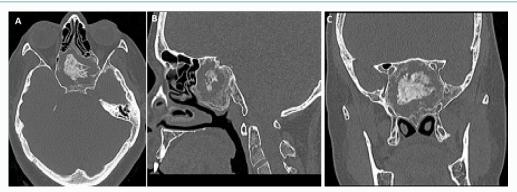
Paranasal sinus computed tomography scans showing a smooth-circumscribed, expansive mass with ossification in the central, originating from the sphenoid bone, located in the upper-posterior of the nasal cavity in axial (A), saggital (B) and coronal (C) planes.
